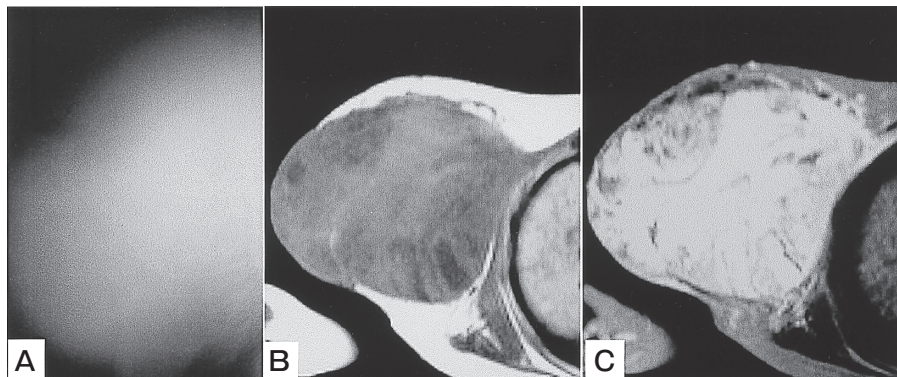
A, Mammography demonstrated a huge tumor in the right breast. Coarse calcification was not observed; B, T1-weighted image of MRI demonstrated a low-intensity and heterogeneous tumor in the right breast; C, The high-intensity of the T2-weighted image implied a cystic lesion with pooling of blood or body fluid.
